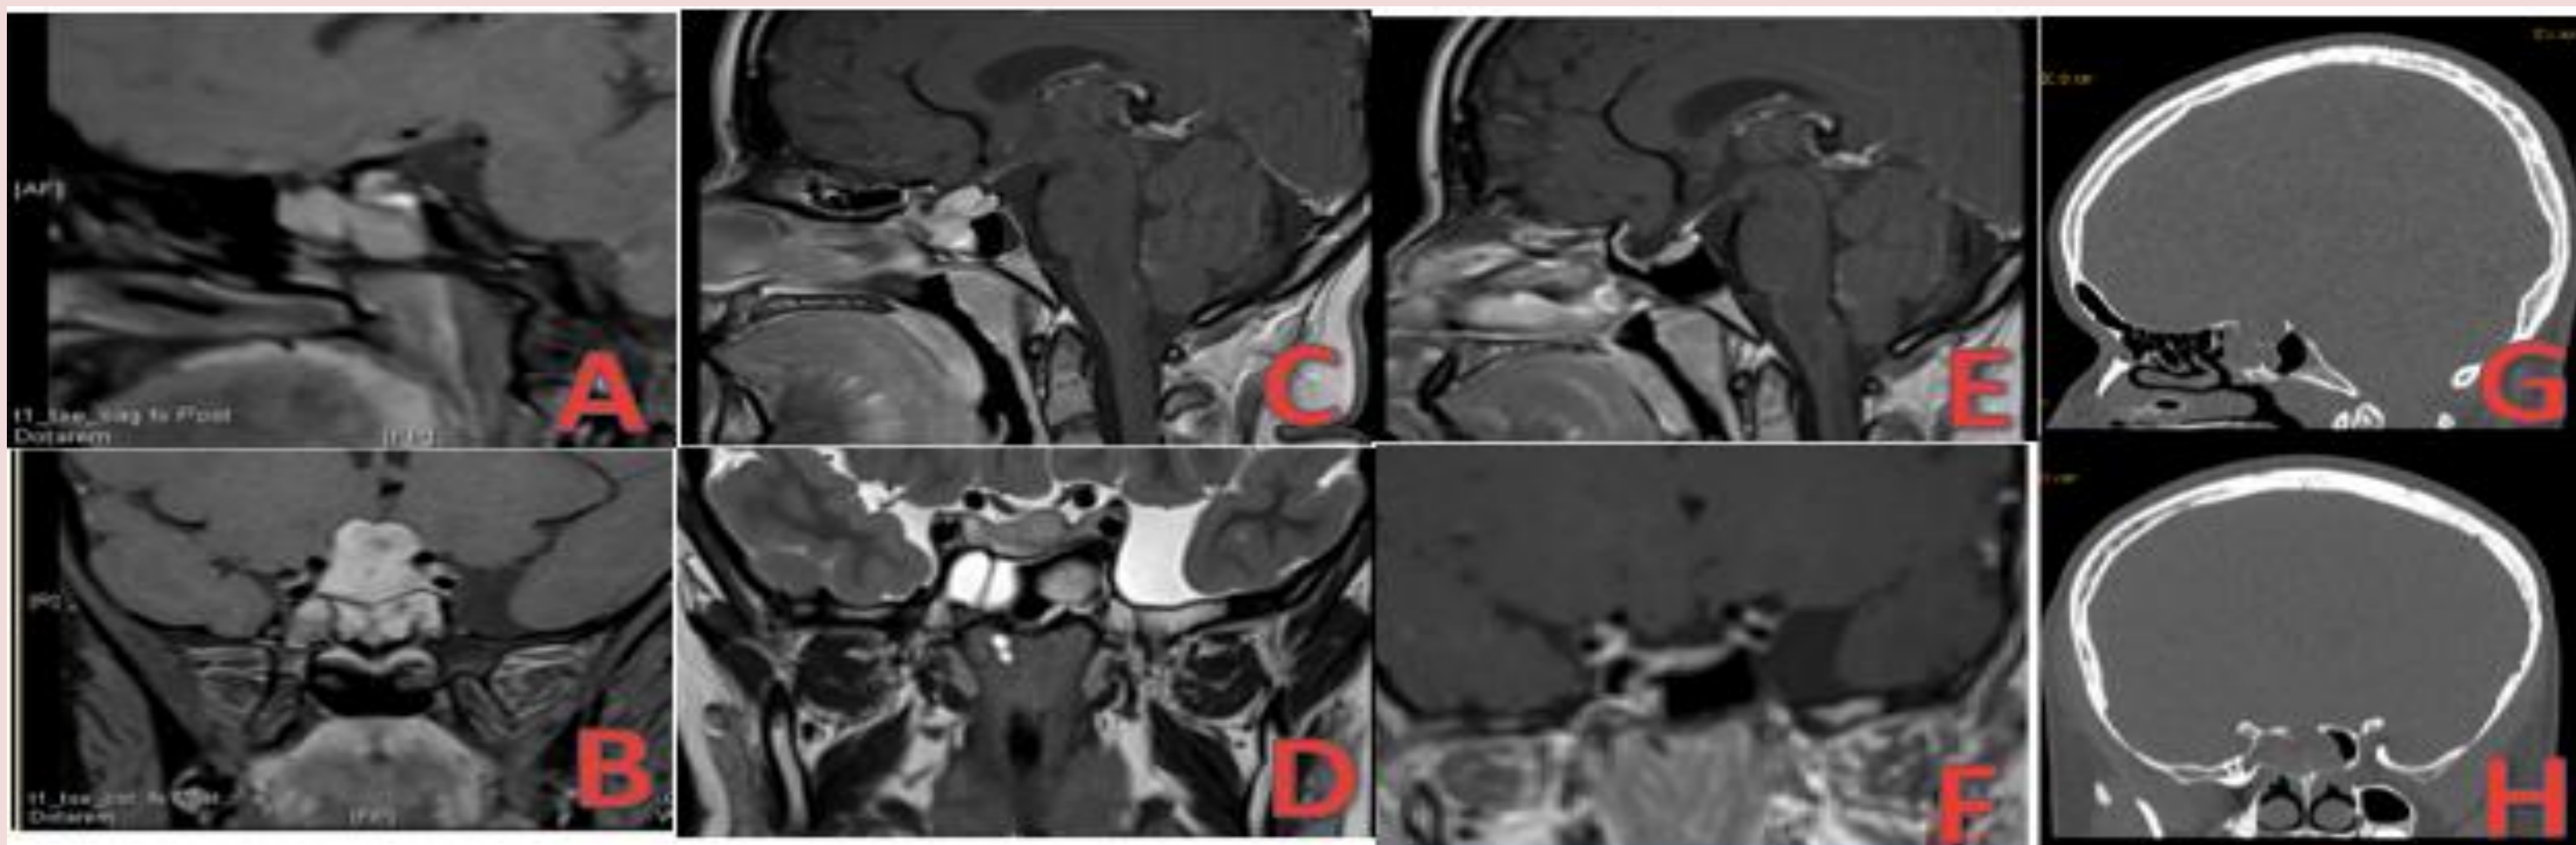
MRI coronal / sagittal contrast enhanced T1w of the pituitary region Surgery
